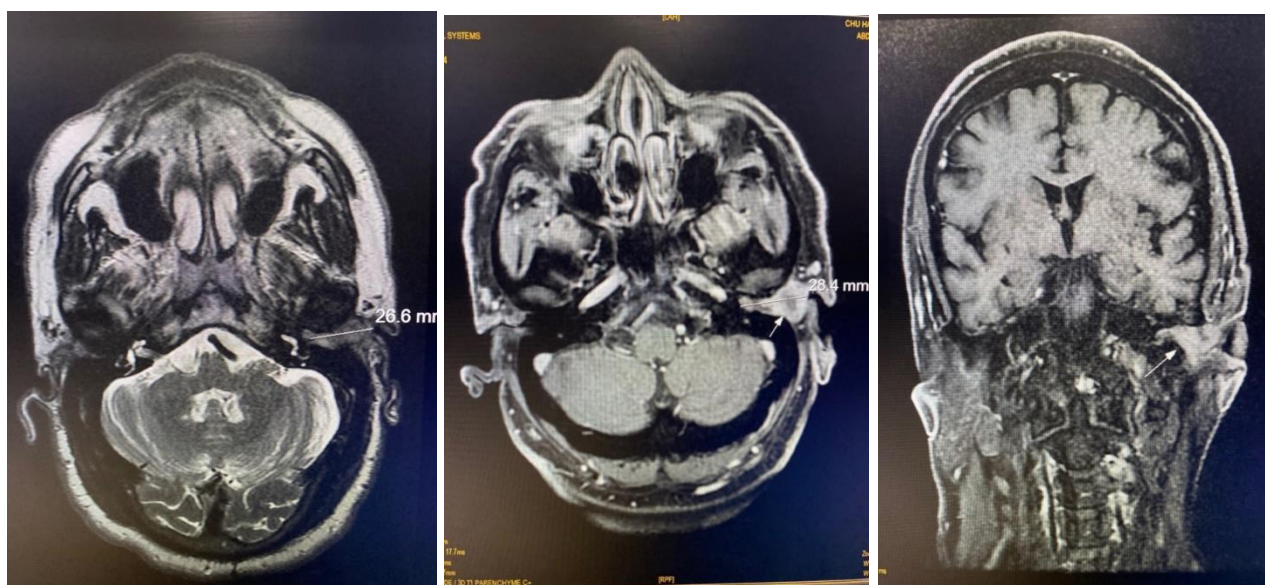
4 & 5: MRI: EAC Tumor: Intermediate signal on T1, Heterogeneous enhancement after contrast injection. Without extensions to neighboring structures
